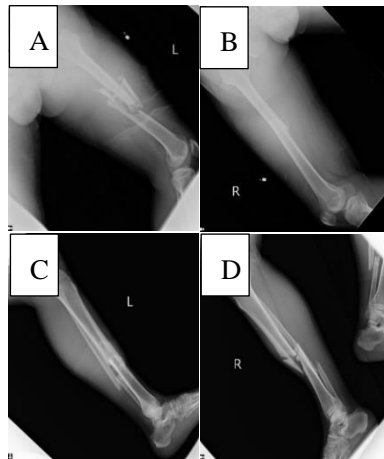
Initial plain radiographs revealed displaced bilateral femoral (A, B), tibial (C, D), and fibular midshaft fractures.
